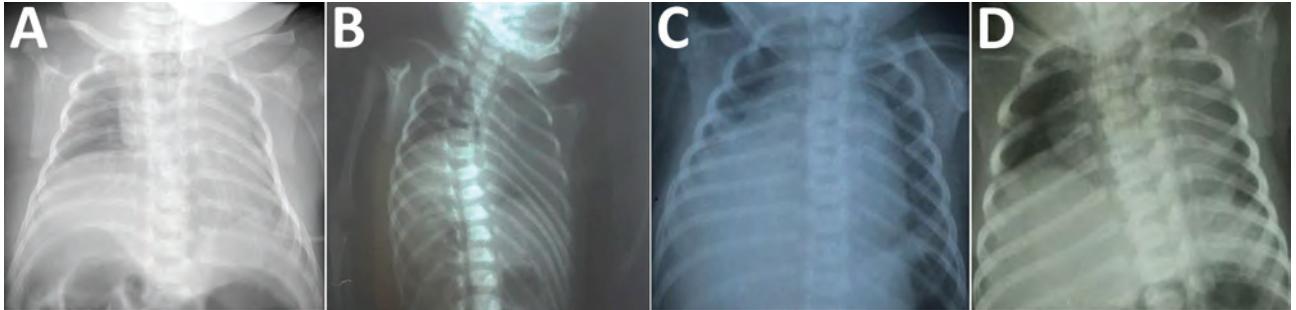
Chest radiographs of infants with congenital Zika syndrome, demonstrating elevation of the right hemidiaphragm. Panels A–D represent patients 1–4, respectively. In each instance, only the right hemidiaphragm was noticeably elevated. All patients also had arthrogryposis (including talipes equinovarus) and died from complications related to progressive respiratory failure.
